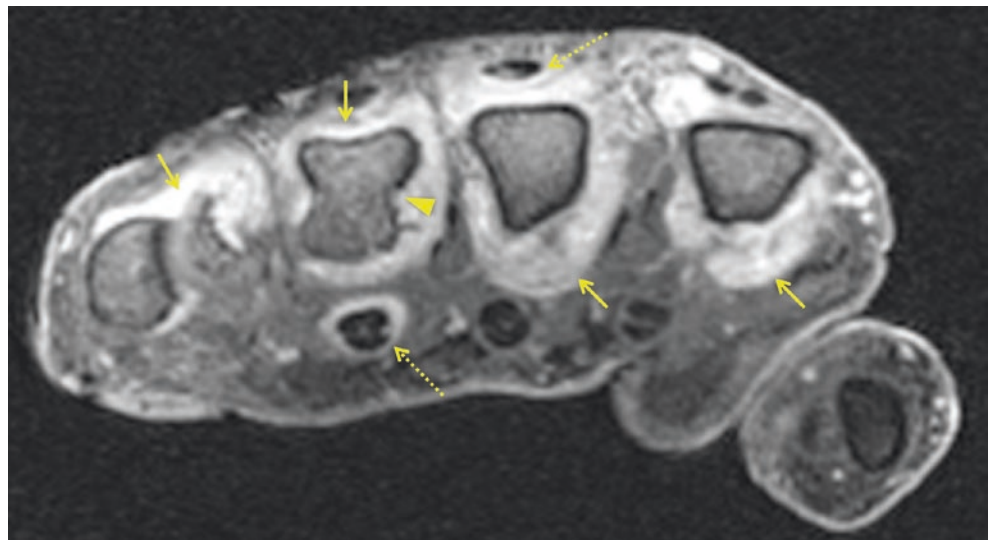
Axial MPR of 3D fat-suppressed spoiled gradient echo (SPGR) MRI post-gadolinium, just proximal to MCP joints in a patient with rheumatoid arthritis. There is extensive enhancing synovitis seen around the metacarpal heads (arrows) associated with erosion in the ring finger metacarpal head (arrowhead). Note also enhancing tenosynovitis around the ring finger flexor and middle finger extensor tendons (dashed arrows)
